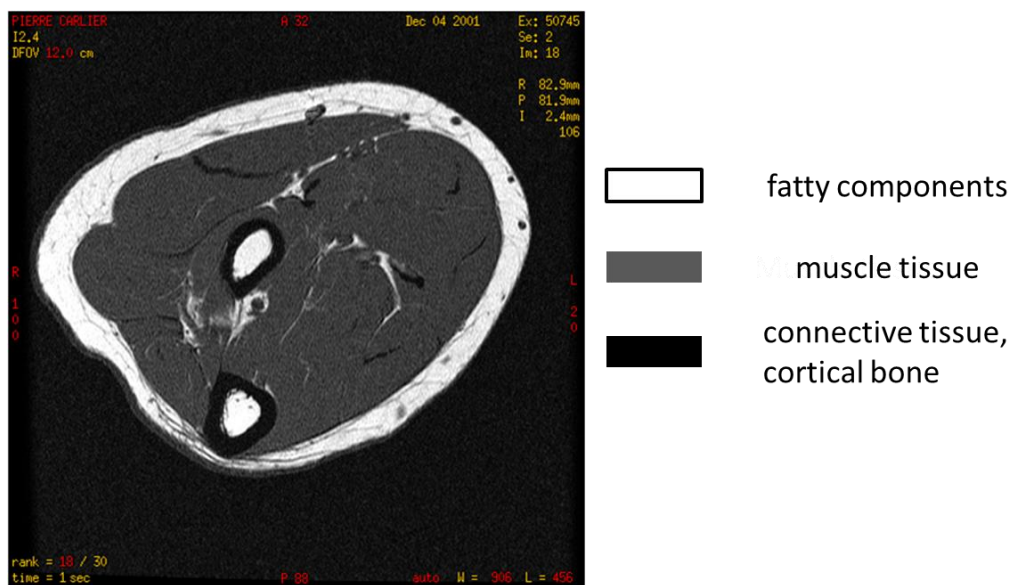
Example of a cross sectional NMR T1-weighted image of the forearm of a healthy subject. Muscle tissue, fatty components, fascia and cortical bone may be easily identified.
